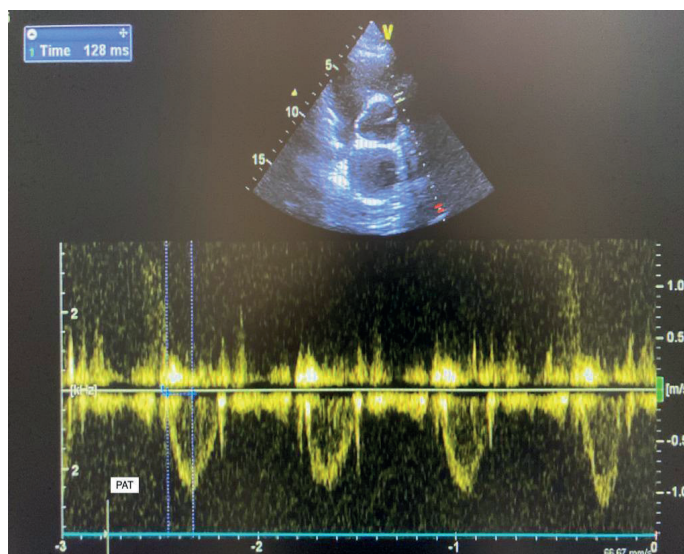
Echocardiographic image of PAT measurements
